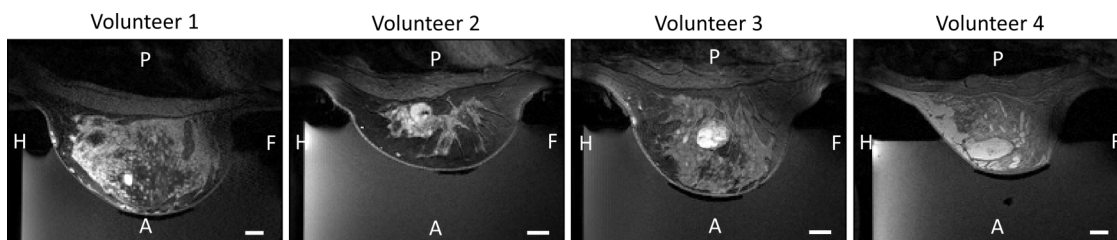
Contrast-enhanced T1w MR images of all four volunteers (sagittal view) that demonstrate the varied breast heterogeneities. White scale bar represents 1 cm. *P* = posterior; *A* = anterior; *H* = head; *F* = foot.
